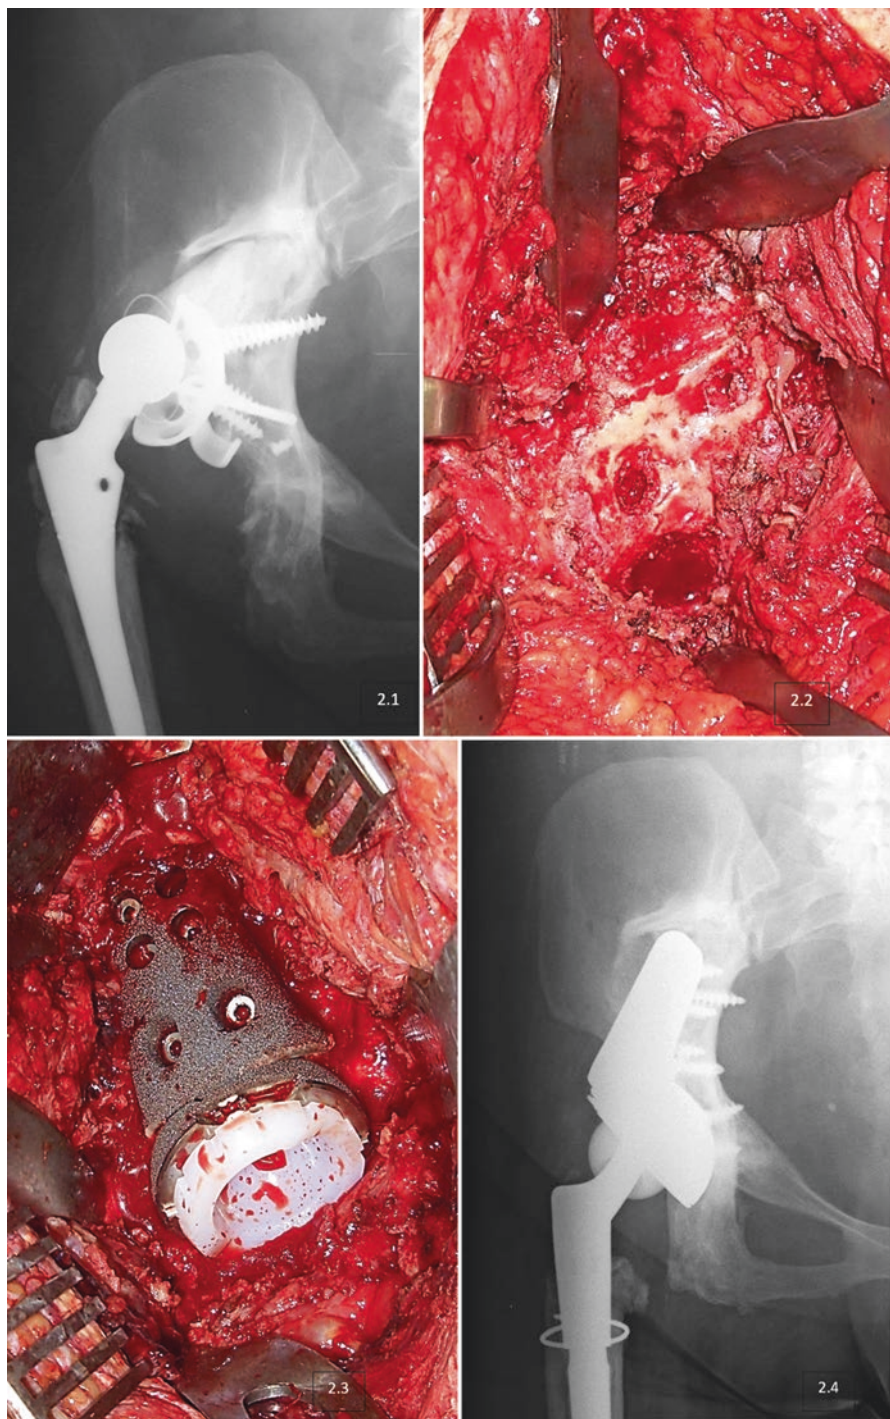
2.1: Acetabular defects Paprosky type IIIA. 2.2: Intraoperative view. 2.3: Iliac buttress. 2.4: Postoperative radiograph at 7 years
